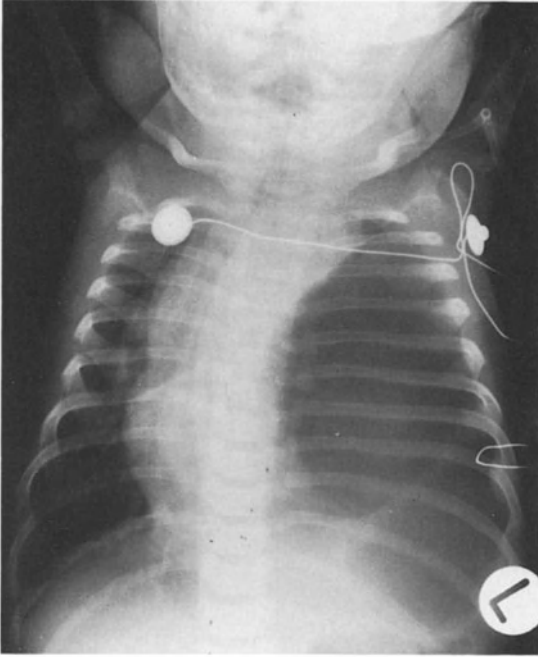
Chest X-ray of infant with large air-containing cavity in the left hemithorax. Is it due to a pneumothorax or is it a distended stomach?
